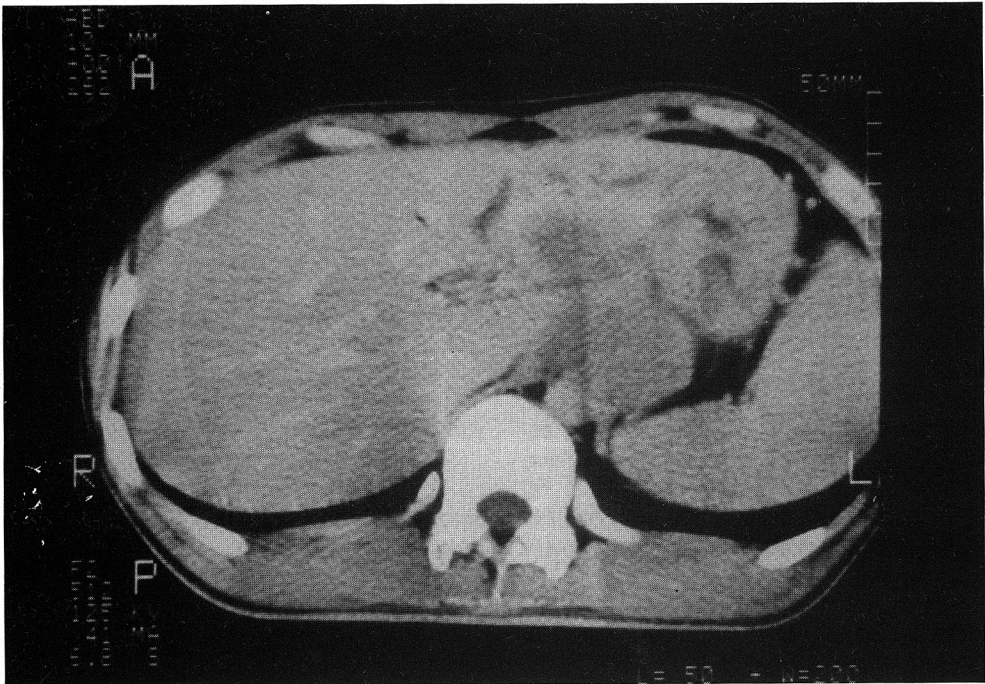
The follow-up CT scan showing a much regressed abscess cavity..
